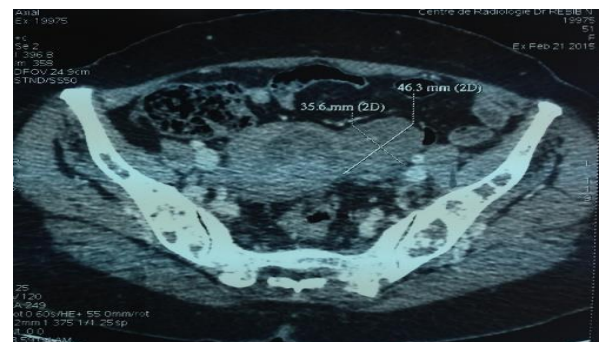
CT scan of pelvic mass
